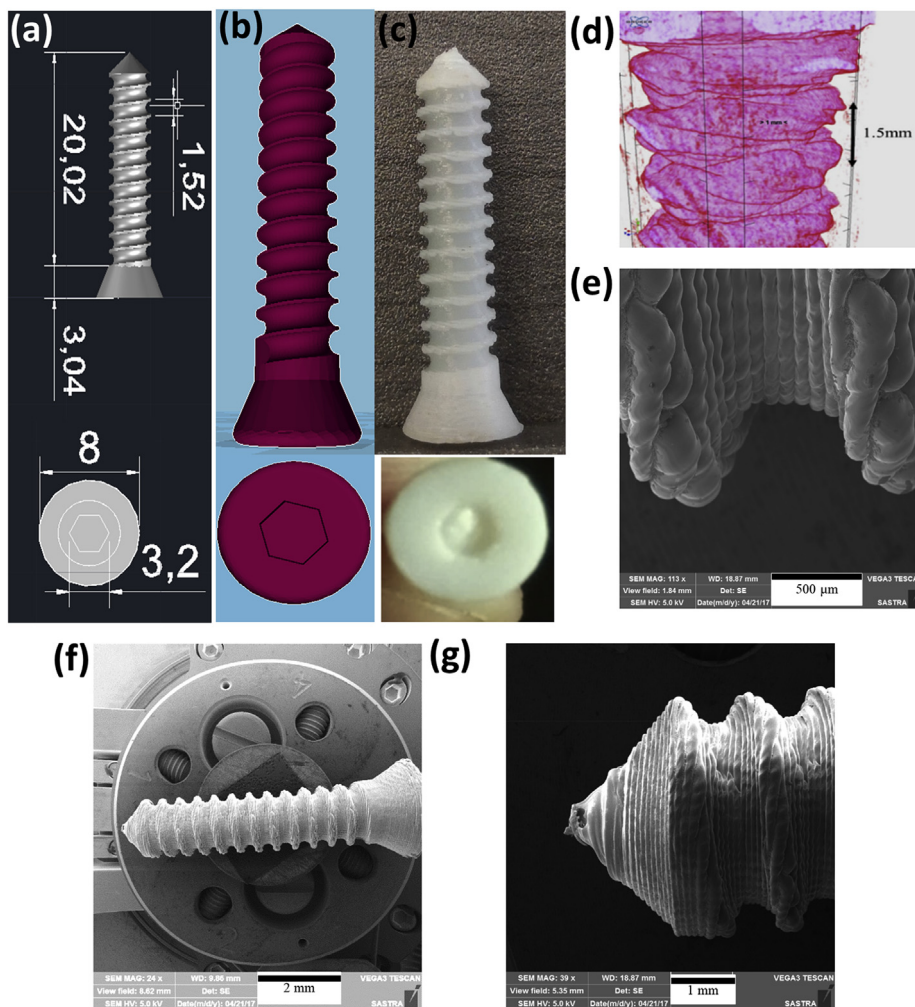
(a) AUTOCAD designed screw in mm; (b) STL file shows the 3D printable screw model; (c) 3D Printed cortical screw; (d & e) pitch length of printed screw measured using micro CT and SEM (f & g) uniform layers were observed forming rough surface from head till tapered end.
